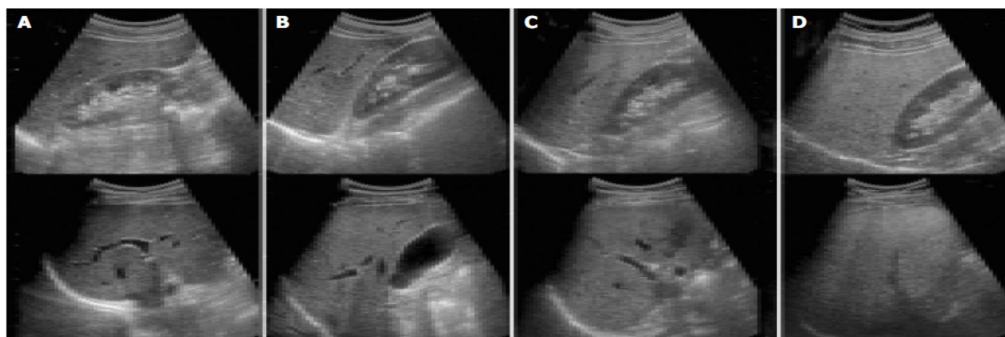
ULTRASOUND GRADING OF LIVER STEATOSIS :^[63]
